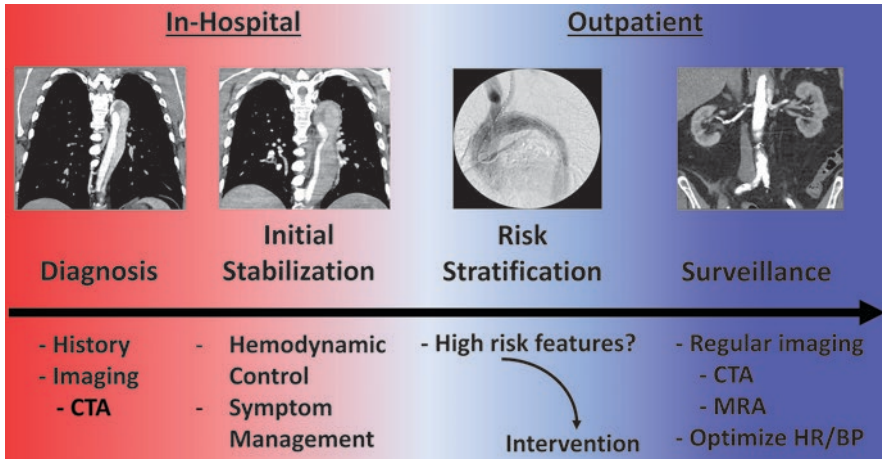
Care paradigm for medical management of type B acute aortic syndromes. Initial care of type B acute aortic syndromes centers on diagnosis and hemodynamic stabilization. High-risk phenotypes that may benefit from intervention should be recognized. As patients transition from the hospital to the outpatient setting, regular follow-up with surveillance imaging and optimal heart rate (HR) and blood pressure (BP) control are crucial to prevent complications. *CTA* computed tomographic angiography, *MRA* magnetic resonance angiography
